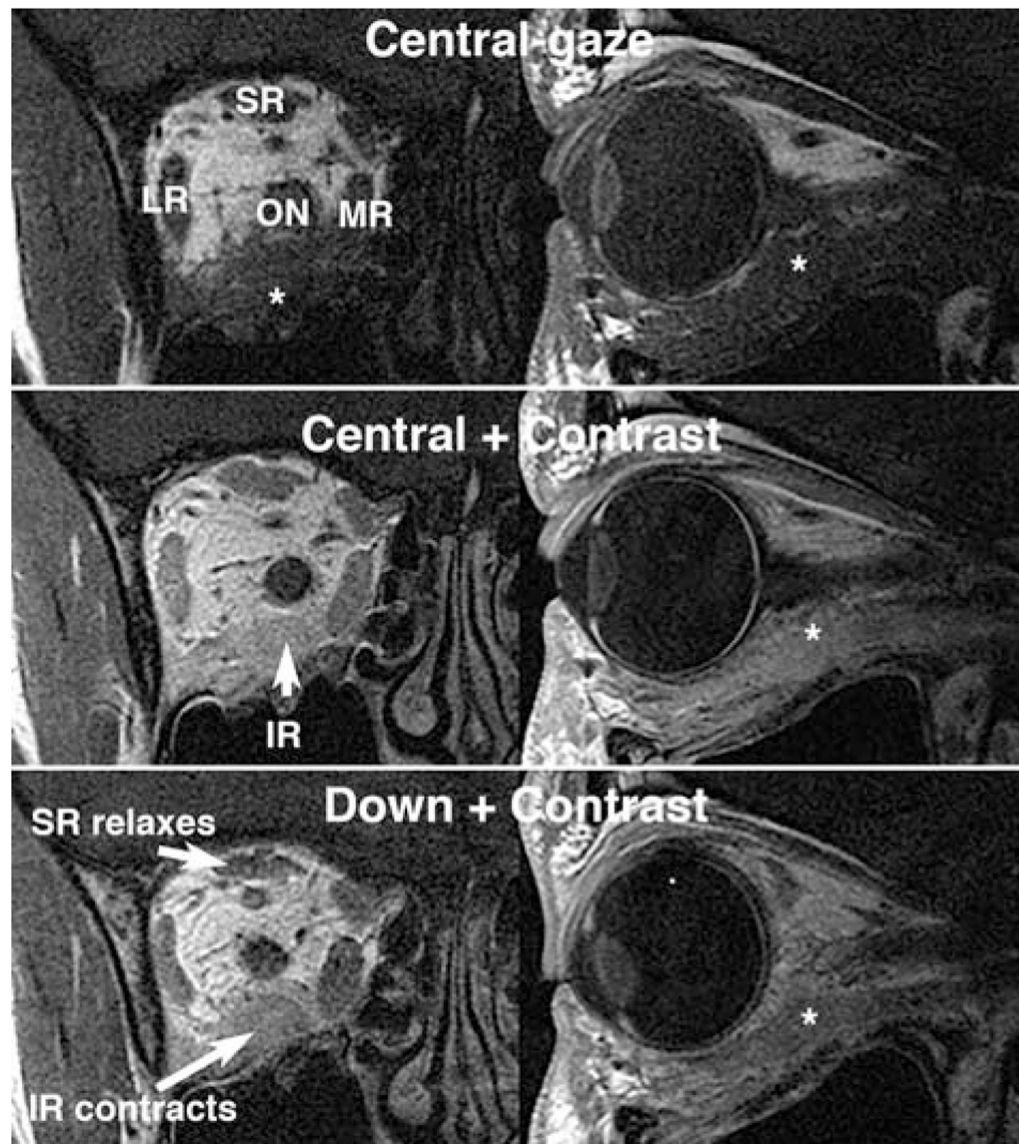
Case 12. Coronal (left column) and sagittal (right column) T2 MRI in central (top and mid rows) and down gaze (bottom row) showing a functional IR in normal continuity with the scleral insertion surrounded by a large contrast enhanced mass (*). Right IR shows changes in attempted infraduction.
